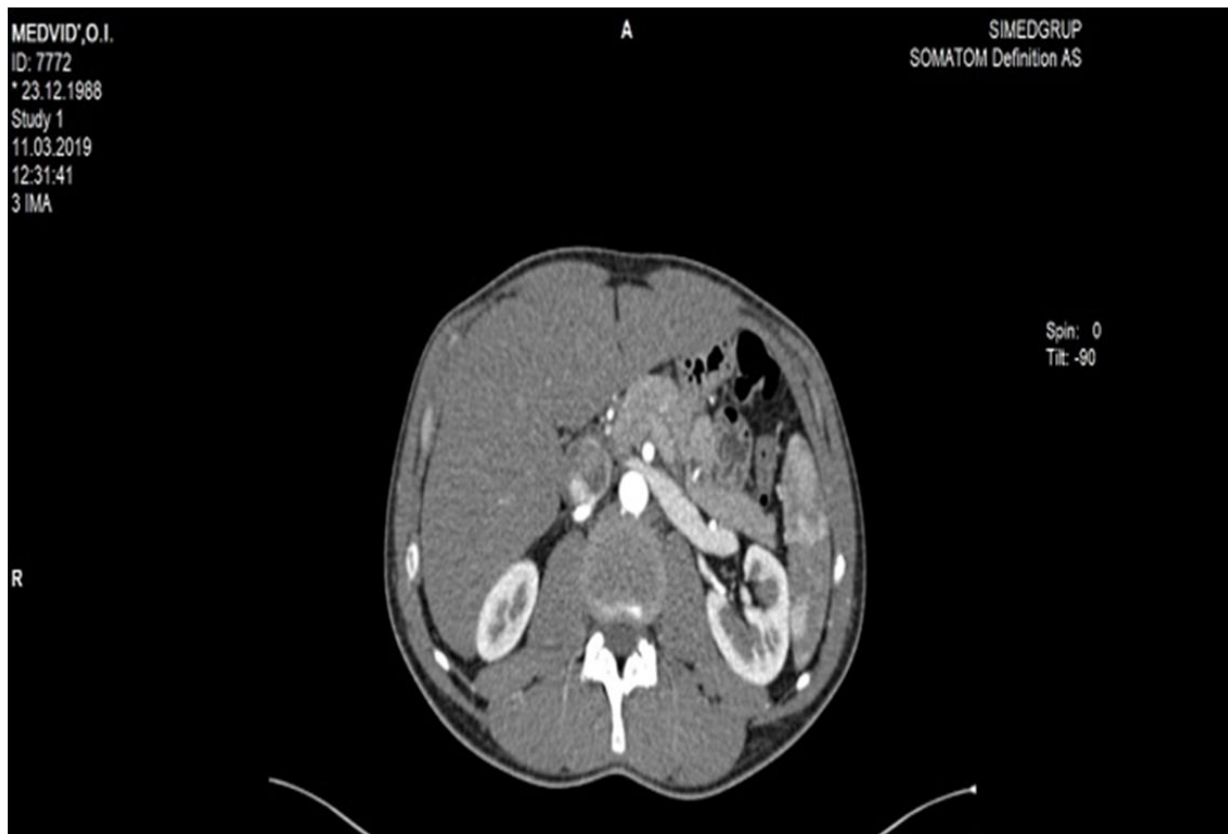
CT angiography of a patient with “the nutcracker syndrome”
